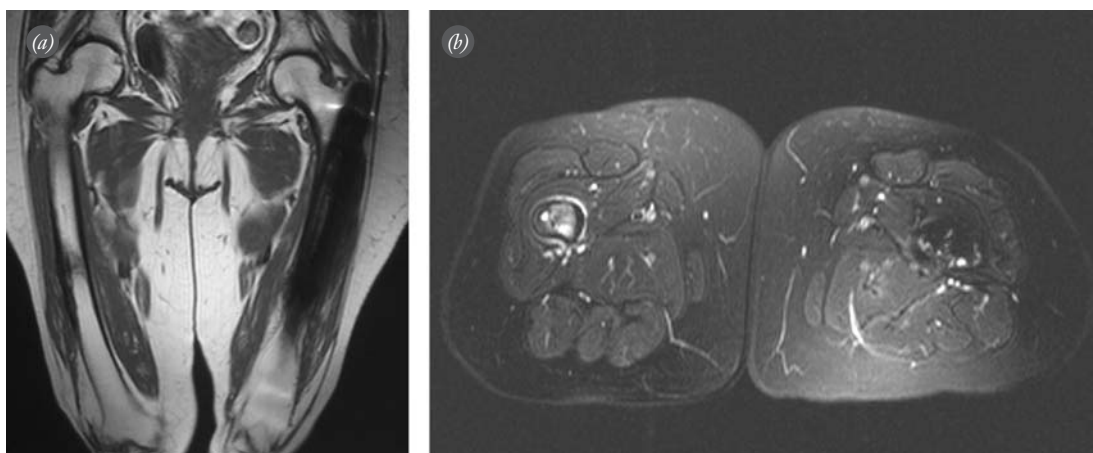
MR images of patient no. 5. MRI sections of impending fracture localized at the right femoral shaft. (a, b) Unicortical fracture line localized at lateral cortex of femoral shaft, medullary and soft-tissue edema seen around fracture site and periosteal reaction with cortical thickening can be seen.
